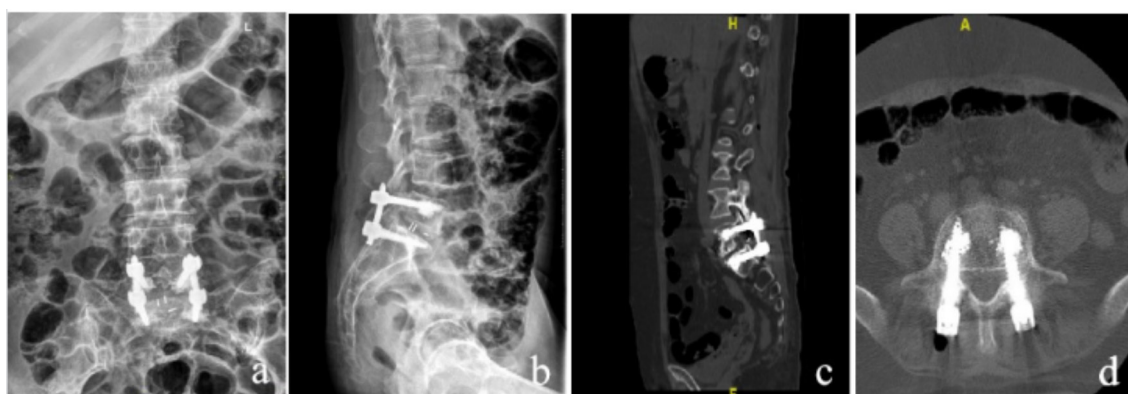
a-b, 3 days postoperative frontal and lateral radiographs of the lumbar spine, with the lumbar internal fixation in place and no leakage of bone cement. c-d, 3 days after surgery, CT of the lumbar spine showed good position of the pedicle screws and satisfactory diffusion of bone cement around the screws in the vertebral body with no leakage.
